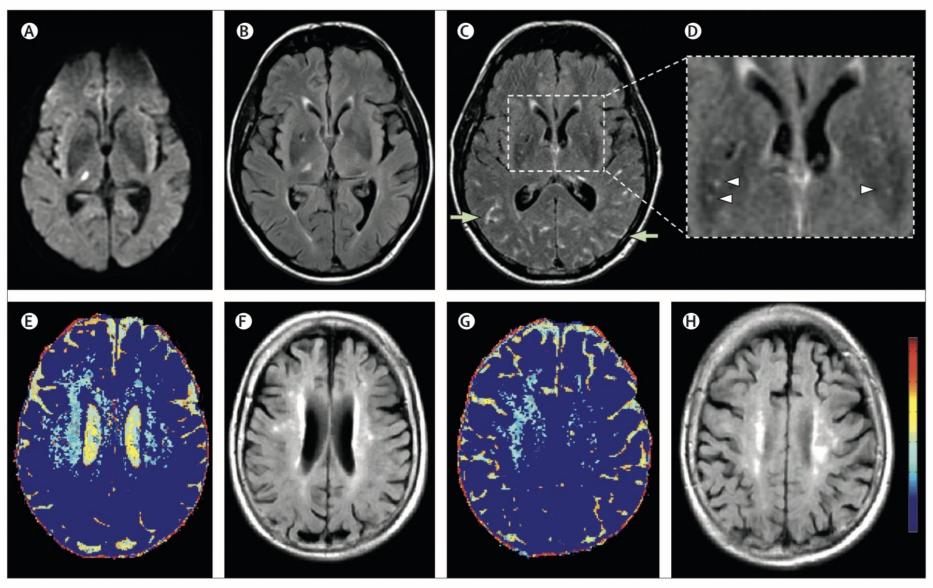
MRI of cerebrovascular endothelial permeability
